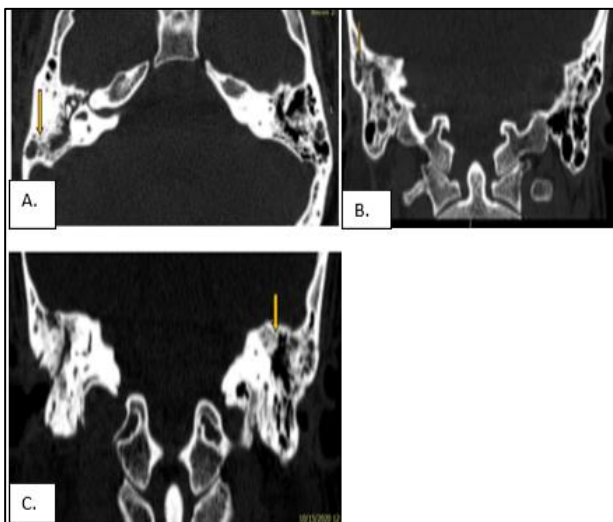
(A) Axial HRCT temporal bone showing Fracture of right petrous bone + heamotympanum. (B) Coronal view showing fracture of right petrous bone. (C) Coronal view showing fracture of left petrous bone.
